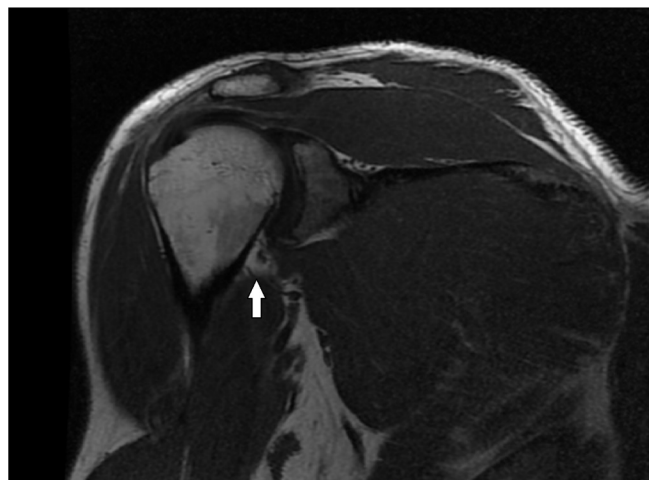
MRI confirms PM rupture.
